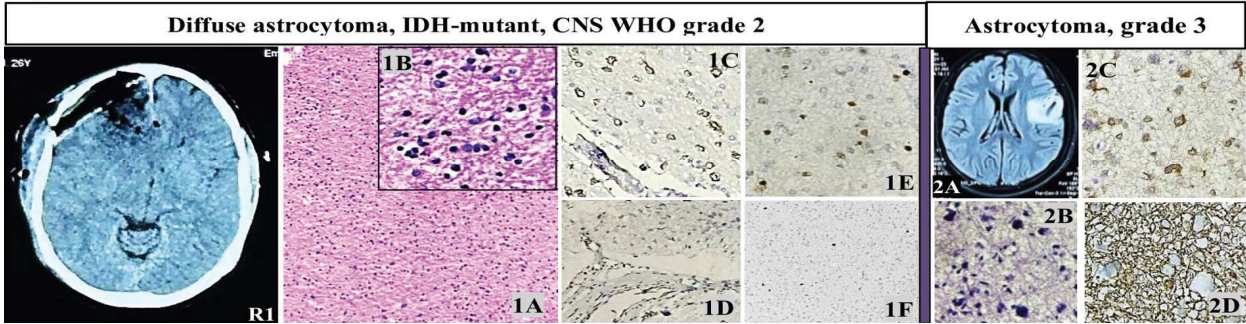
R1 MRI showed a hypodense, non-enhancing left frontal lesion with ill-defined margins and mild mass effect. Histomorphology (Fig. 1A-1B) showed increased cellularity with mild atypia of tumor cells in a dense fibrillary background (H&E10X & Inset 40X). IHC showed IDH mutation (Fig. 1C, 40X), ATRX loss (Fig. 1D, 40X), p53 positivity (~10%) (Fig. 1E, 10X), and a low Ki-67 index. (<5%) (Fig. 1F, 10X) in tumor cells.
